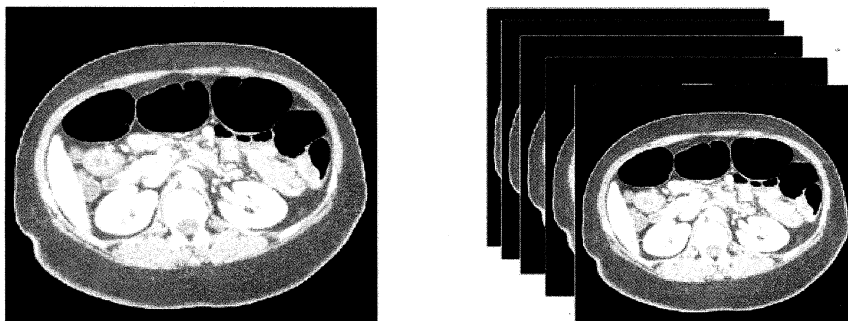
(a) A typical colon image, (b) A stack of CT colon images
